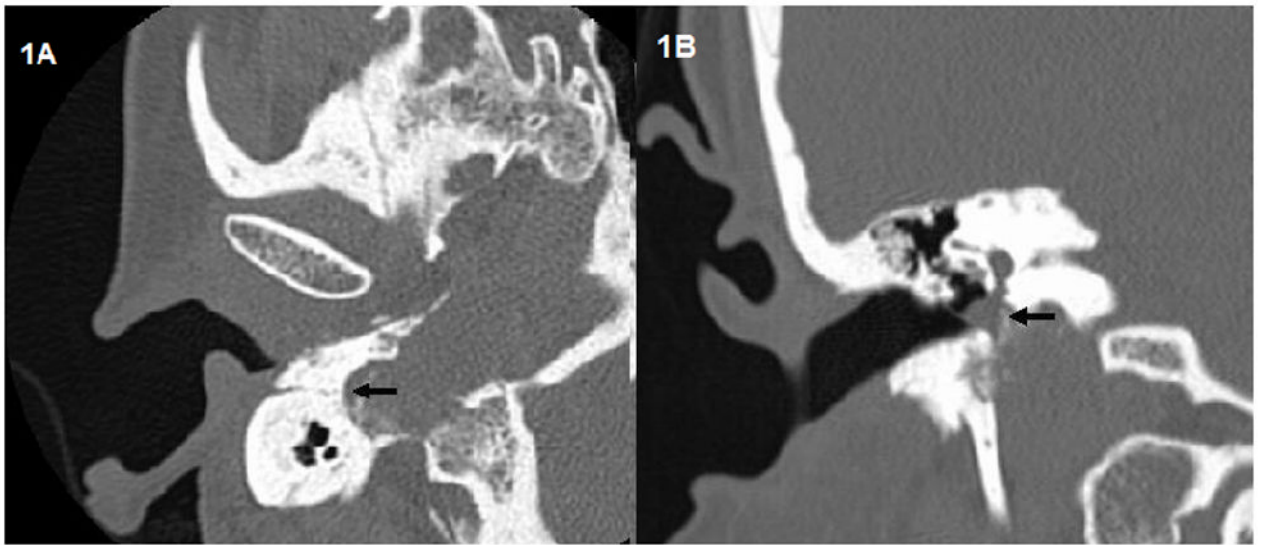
HRCT image demonstrating a 1.8 X 2.5 cm erosive right jugular foramen mass consistent with a Fisch type C2 glomus jugulare tumor with involvement of the mastoid segment of the facial nerve (1A, arrow). The mass was found to be eroding through the hypotympanum into the middle ear space (1B, arrow).
